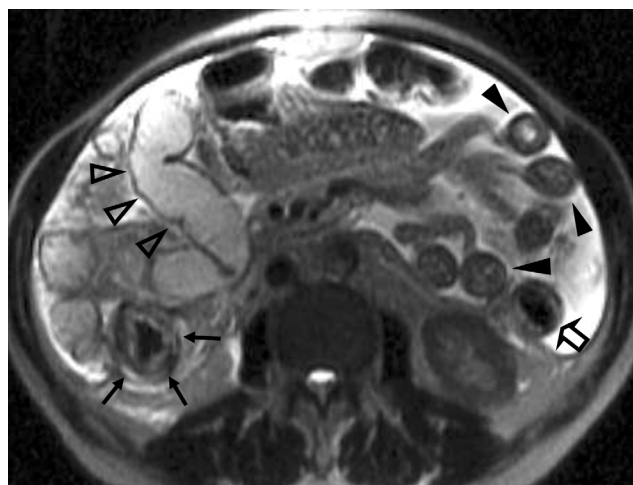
68 year-old man with moderate cirrhosis. T2-weighted single-shot fast SE image (/186) shows symmetric wall thickening with high signal intensity in jejunum (black arrowheads), ascending colon (black arrows), and descending colon (open black arrow). Markedly dilated right-sided small bowel (open black arrowheads) suggests associated ileus.
